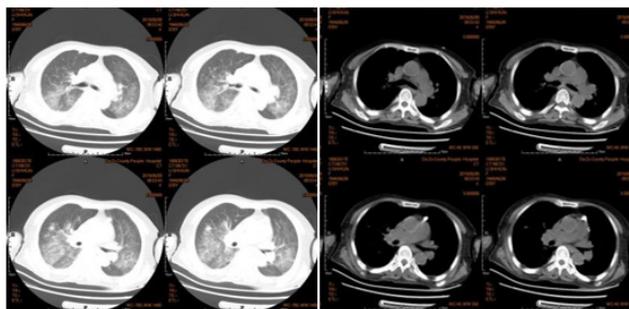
Chest computed tomography scan shows an increase in bronchial vascular bundles in both lungs, disorganized alignment, and diffuse large hyperdense shadows in both lungs with blurred boundaries.
